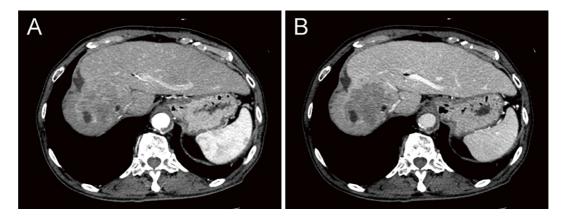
Contrast-enhanced computed tomography on admission day 17. The tumor exhibited restored arterial enhancement (A) with washout on portal phase (B).
